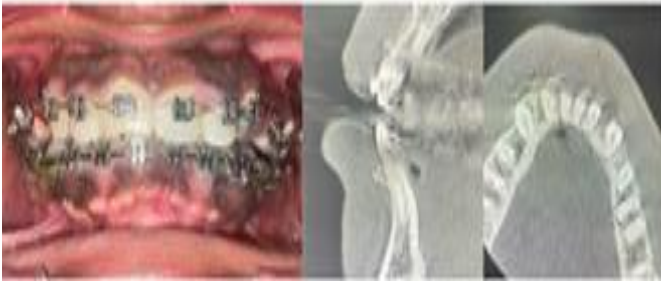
Pre-operative clinical photograph and corresponding sagittal and axial CBCT sections demonstrating gingival overgrowth clinically and prominent buccal alveolar bone exostoses in the anterior maxillary region, identified 18 months after completion of orthodontic treatment in a 31-year-old female patient. To further evaluate the extent and characteristics of the bony overgrowths, a cone-beam computed tomography (CBCT) scan and a lateral cephalogram were obtained for the patient. The CBCT images revealed well-defined, convex, bony protuberances along the labial surfaces of the alveolar bone in both the maxillary and mandibular anterior regions. These exostoses presented as well-defined, dense cortical outgrowths, projecting from the facial surface of the alveolar bone and clearly distinguishable from the adjacent structures. On the lateral cephalogram, the labial exostoses were visible as radiopaque, oval-shaped elevations on the facial surfaces of the anterior alveolar bone, more prominently noted in the maxilla.
